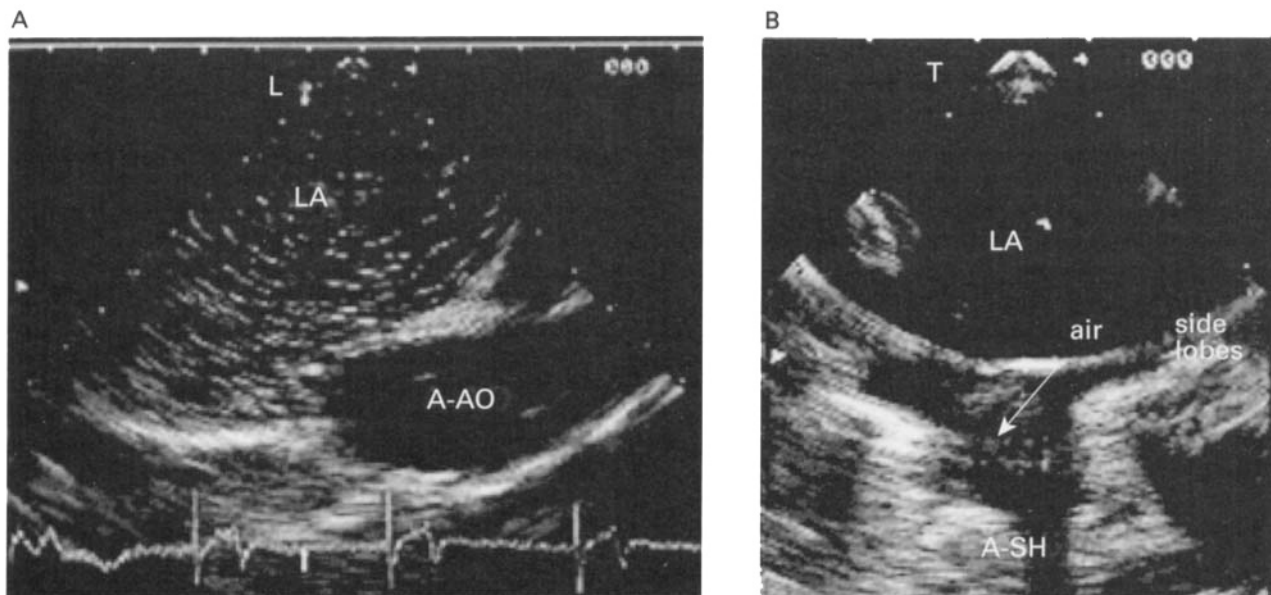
Transoesophageal echocardiogram showing retained intracardiac air: (A) bubble form and (B) pooled form. A-AO = ascending aorta, A-SH = acoustic shadow, LA = left atrium.
